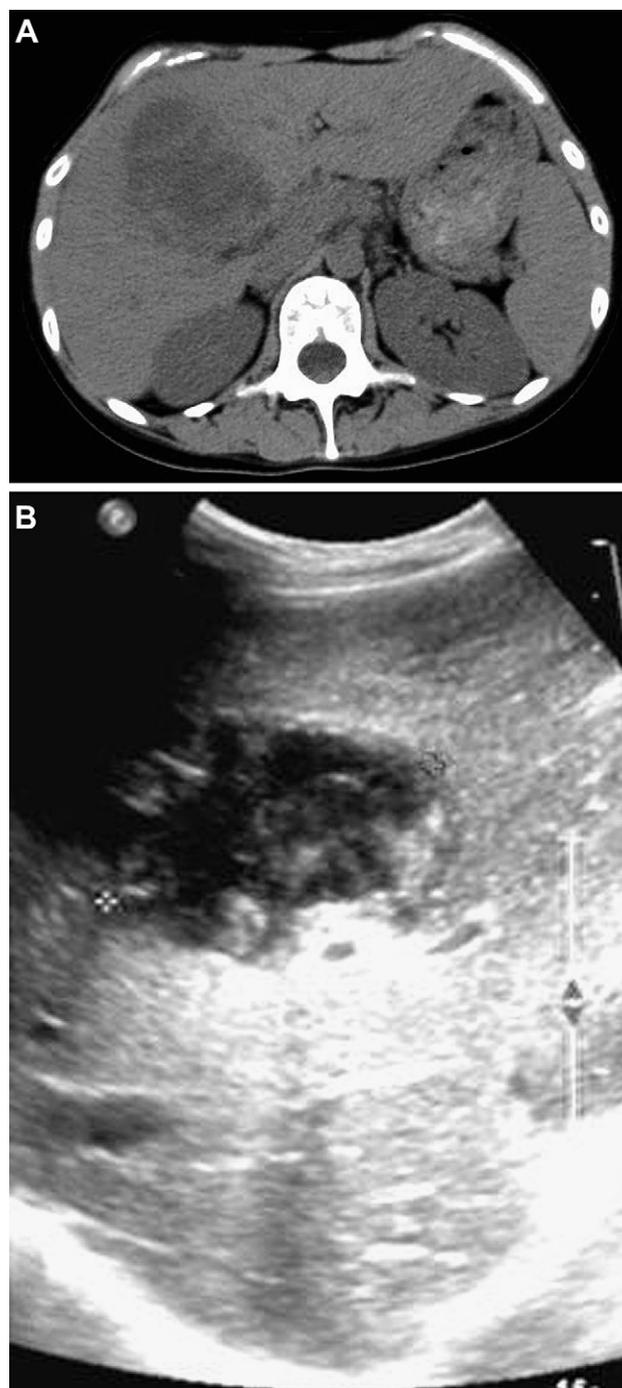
(A) Abdominal computed tomography without intravenous contrast performed upon first presentation revealed a large, low-attenuated lesion with internal septa in the right lobe of the liver. (B) The lesion was of mixed echogenicity.
